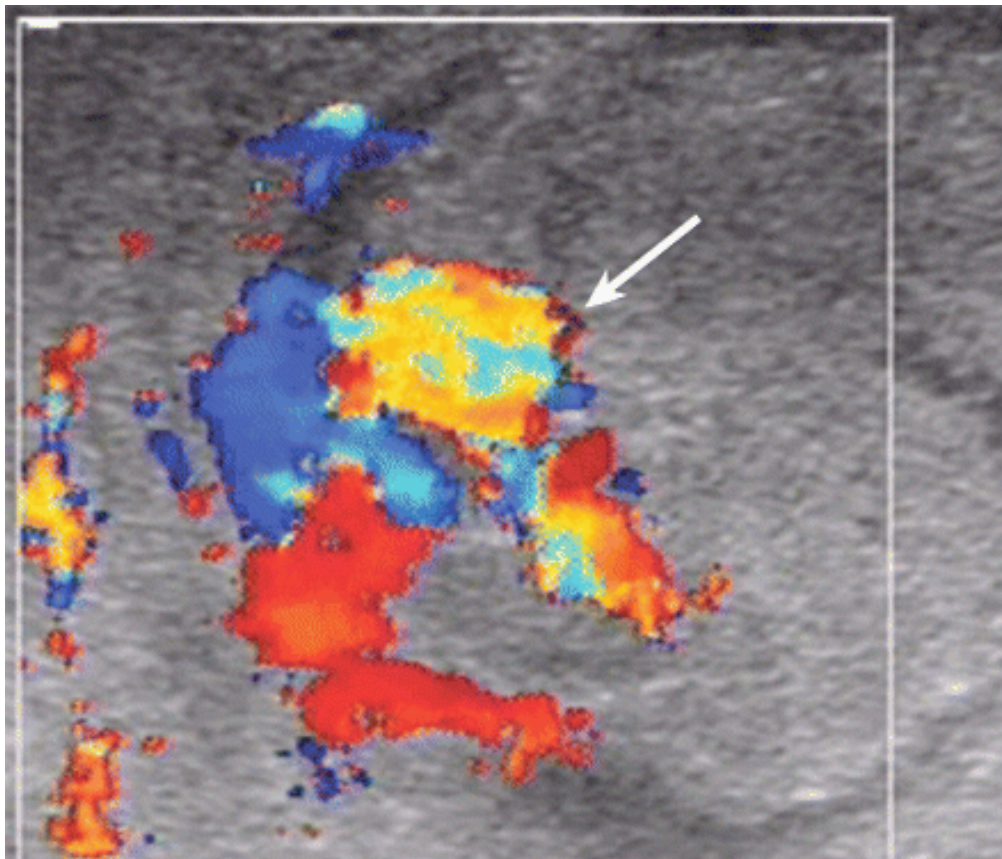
The above photograph is a Color Doppler US image of the right testis in a patient who developed a testicular pseudoaneurysm represented by a focal area with a mosaic of colors (arrow) following scrotal trauma. (radiographics.rsna.org)
